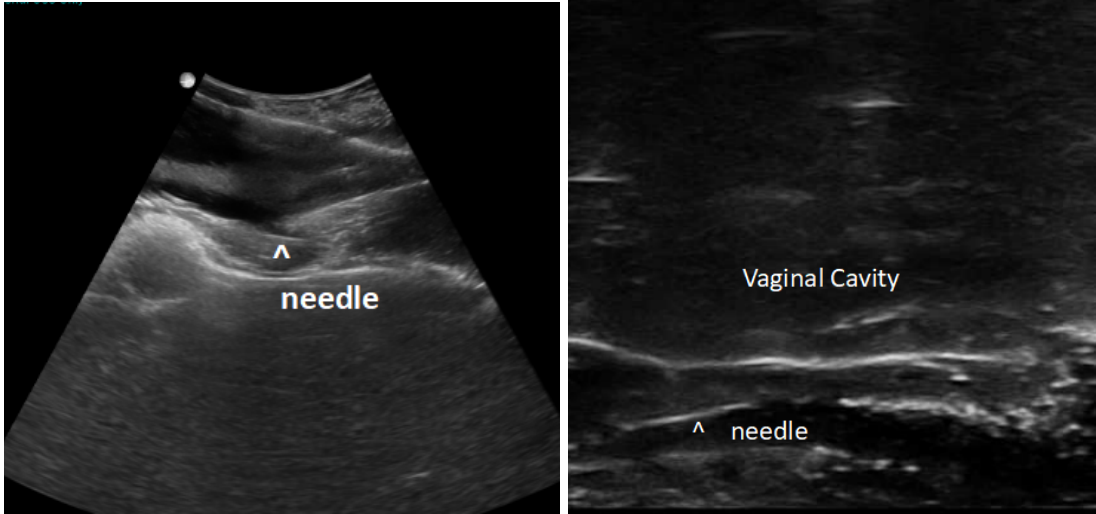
Needle was visible under ultrasound in the 3rd prototype. (left) Needle was visible under abdominal ultrasound. (right) Needle was also visible under transrectal ultrasound.
